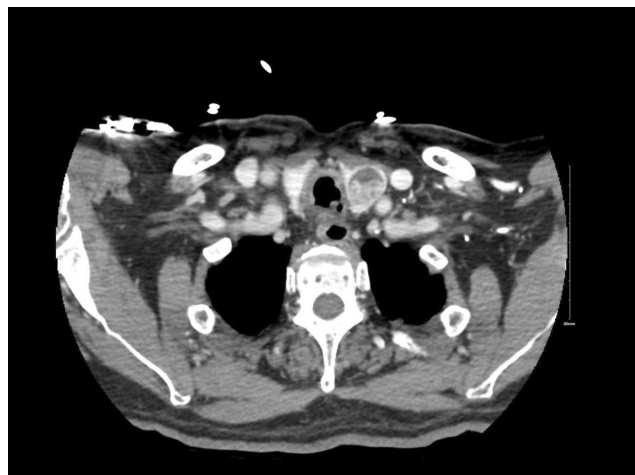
Axial CT neck demonstrating a 4 mm polypoid tracheal lesion. An incidental left thyroid mass is seen as well.
